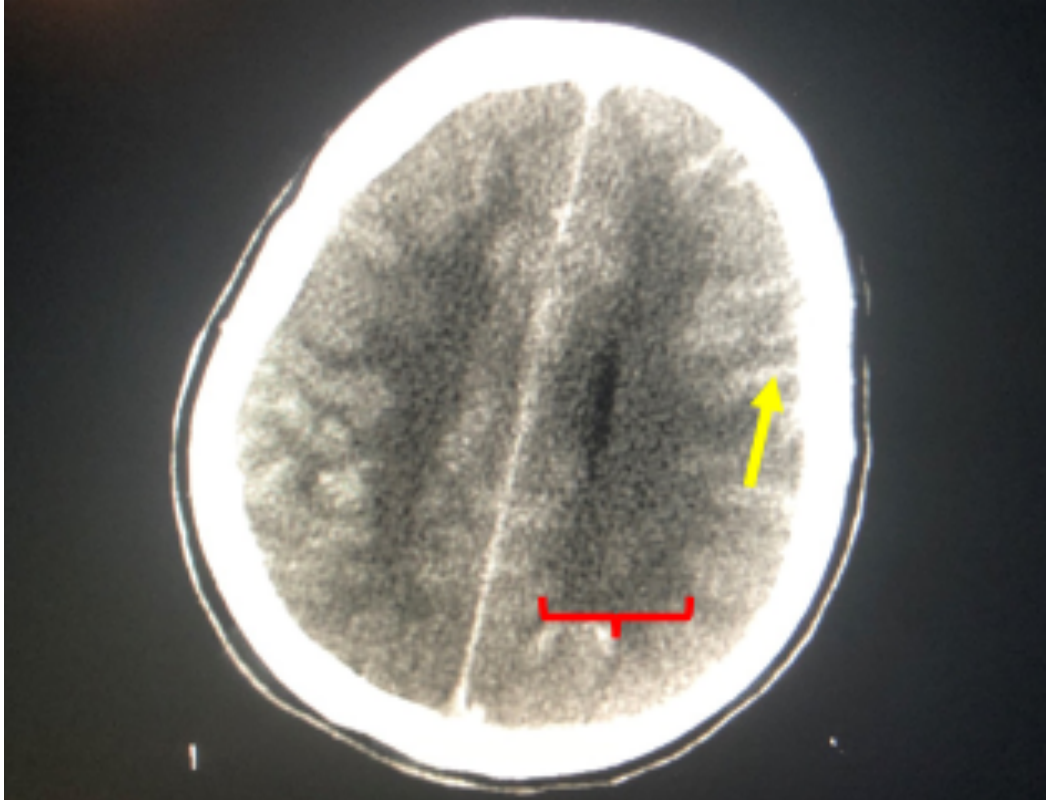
Brain CT without contrast shows the area of subarachnoid blood (arrow) and an area of noticeable cortical and white matter edema (bracket).
